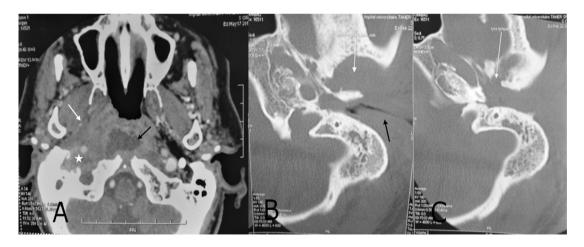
A. Axial cervical CT image: retropharyngeal abscess (black arrow) with parapharyngeal extension and internal jugular vein thrombosis (white arrow) complicating a necrotising external otitis. B. Axial CT image: thickening and enhancing soft tissue of the external canal (black arrow) with a subluxation and arthritis of the temporo-mandibular joint (white arrow). C. Axial CT image: Tympanic part of the temporal bone lysis.
